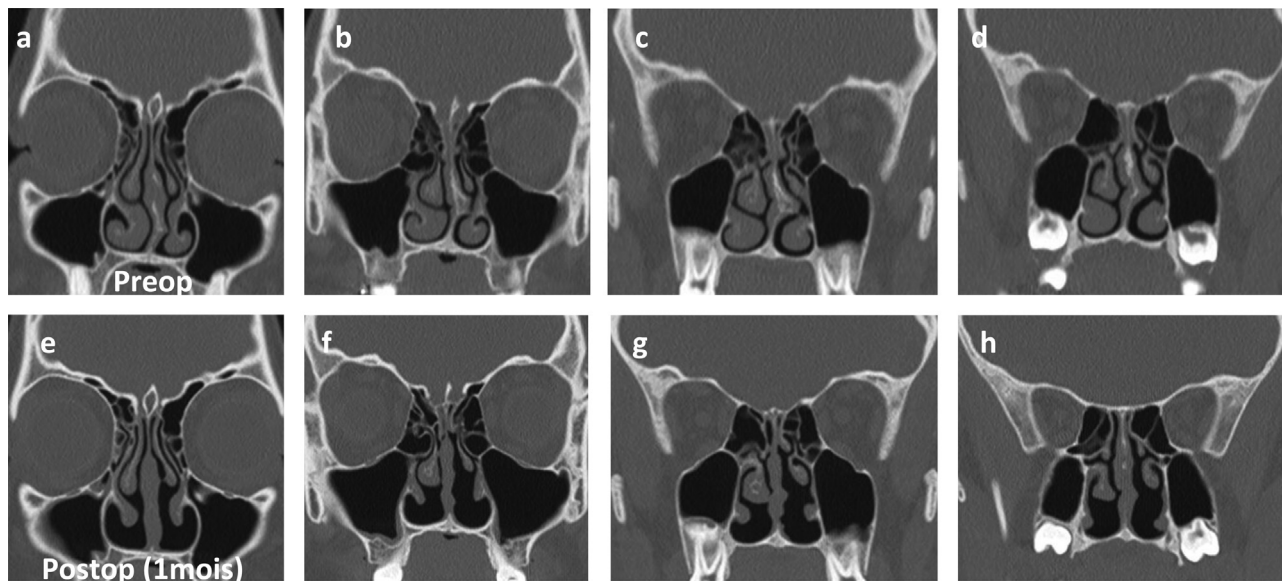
CT slices of chronic nasal dysfunction associating anosmia and nasal obstruction (a–d), relieved by surgery (e–h); a: anterior olfactory clefts, each bordered by the cribriform plate above, septum within and anterior ethmoturbinat outside, with gaseous content; b–d: posterior olfactory clefts, each bordered by the cribriform plate above, septum within and posterior ethmoturbinat outside, forming the olfactory cleft recesses, which have lost their gaseous content on these three scans; e: unchanged postoperative anterior olfactory cleft aspect and conserved inferior meati after inferior turbinate reduction turbinoplasty and correction of preoperative septal deformity; f–h: the olfactory cleft recesses have recovered gaseous content, inferior meati are present, and septal deformity correction is confirmed on these three scans.
